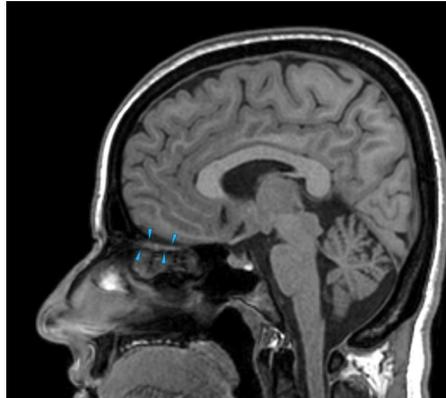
A sagittal T1-weighted magnetic resonance image revealing the boundaries of the right olfactory tract (arrowheads).
